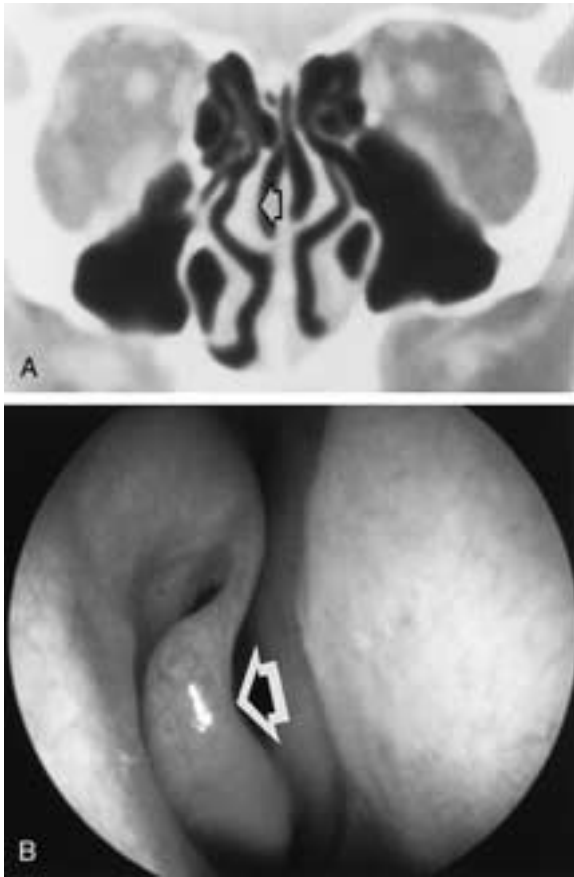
Paradoxical middle turbinate. A, Coronal CT image demonstrates bilateral paradoxical middle turbinates. The right side is highlighted (*solid arrow*). B, Endoscopic view correlates with the CT findings (*arrow*).
